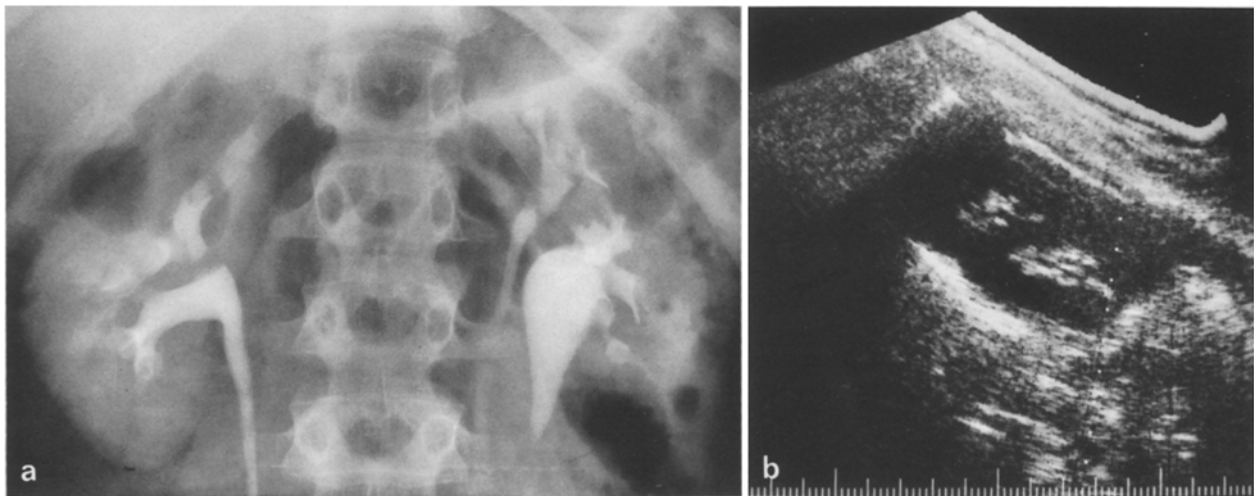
Patient 9. Complete duplication with splitting of renal sinus echo complex. a Excretion urogram showing left duplication. b Coronal sonogram demonstrating splitting of left sinus echo complex
